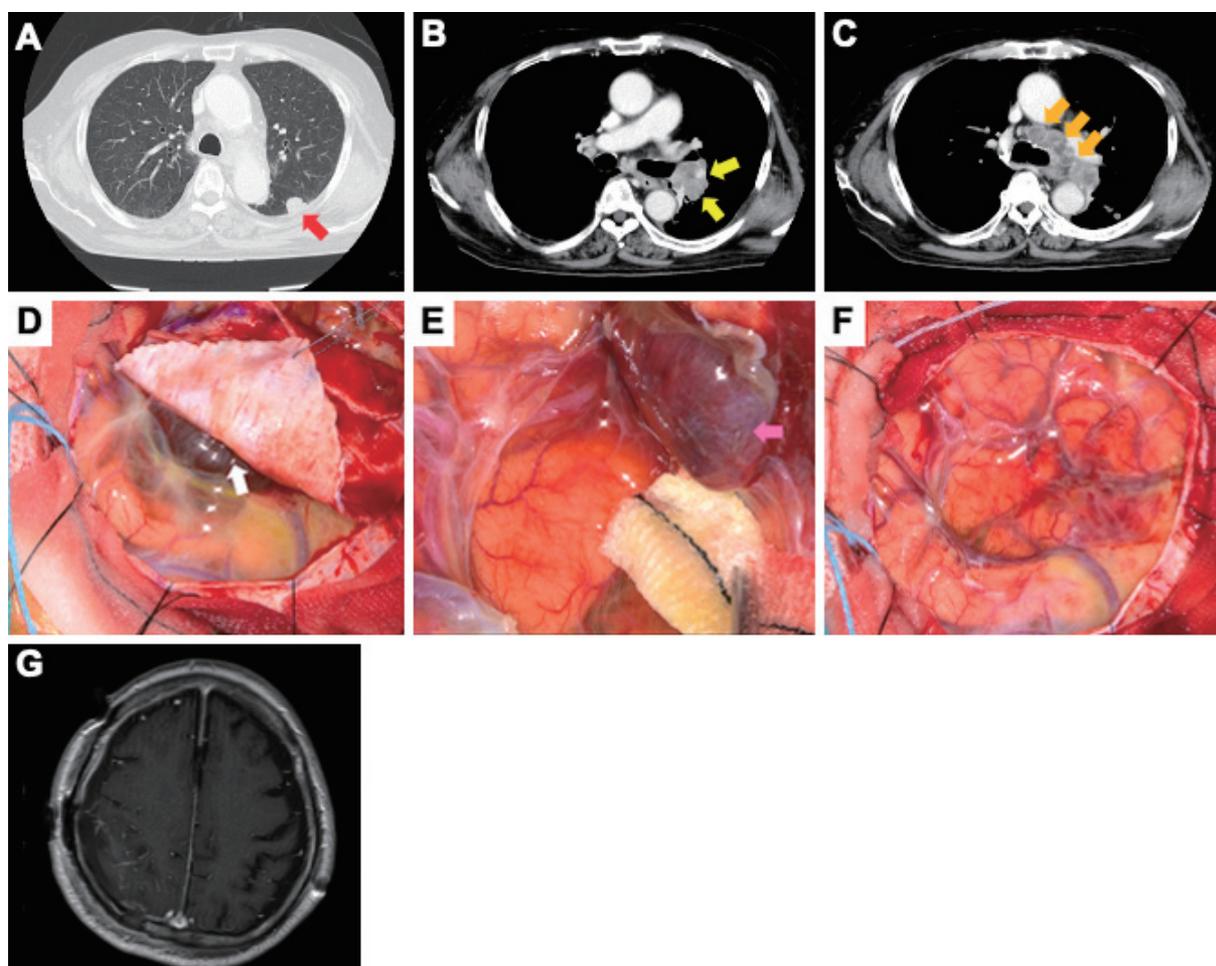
(A-C) Whole-body iodine contrast-enhanced CT showed an irregularly shaped nodule in the left lung (A; red arrow). The lymph nodes of the pulmonary hilum (B; yellow arrow) and mediastinum (C; orange arrow) were swollen, predominantly on the left side. (D-F) Intraoperative photographs. The brain tumor was adherent to the dura mater (D). The solid lesion was resected after puncturing the cystic lesion (D; white arrow), and the solid lesion (E; pink arrow) was sharply demarcated from the surrounding parenchyma and pia mater (E). Gross total resection was achieved (F). (G) Postoperative MR image showing gross total removal of the lesion. CT: computed tomography; MR: magnetic resonance
